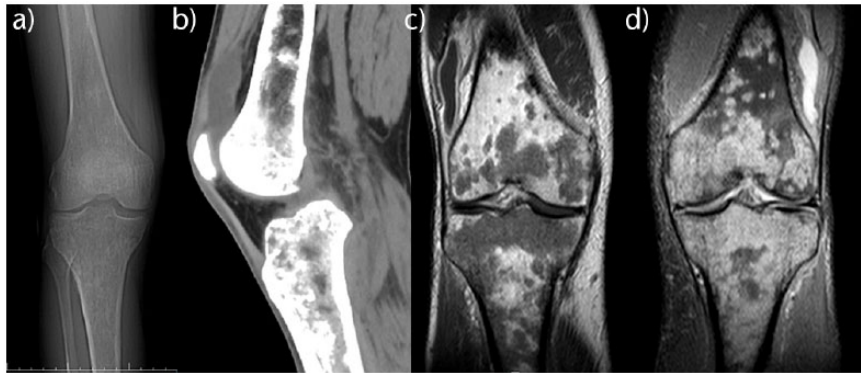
Radiograph of the right knee (a) and sagittal CT scan of the left knee (b) show diffuse heterogeneity of the bones around the knee with mixed osteolytic and sclerotic areas. T1-weighted MRI of the right knee (c) and T2-weighted MRI of the left knee (d) show symmetrical bone marrow heterogeneous signal intensity without lysis of the cortex and bone deformity in a patient with ECD.
